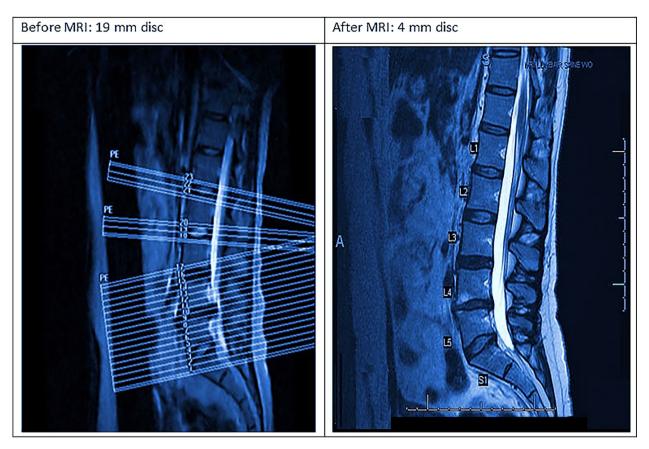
MRI scan before and at the end of the treatment program.
